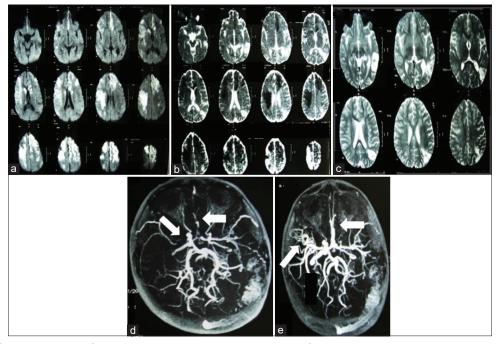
Patient 14: DWI (a) and ADC maps (b) of a patient with the diagnosis of FCA and recurrent ischemic attacks demonstrate the diffusion restriction in the bilateral frontoparietal lobes, right temporal lobe, and bilateral caudate nucleus due to acute ischemia. T2WI (c) shows the chronic encephalomalacia in the left parietal lobe associated with another ischemic attack. MRA (d) shows the occlusion of the right MCA and also the irregularity and stenosis of the bilateral ACA (white arrows). Follow-up MRA (e) after the tPA therapy, patent right MCA and ACA are seen
